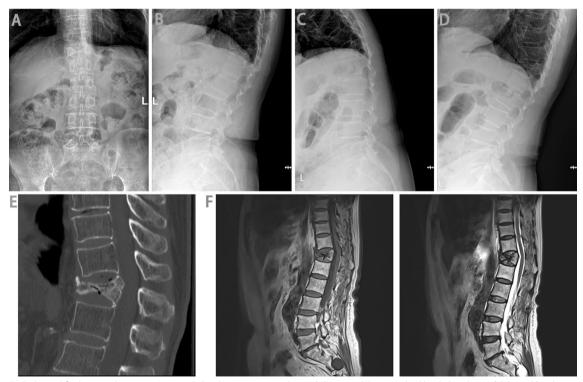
Radiological findings at diagnosis. A Anterior lumbar spine X-ray showed decreased T12 vertebral body height, and B lateral lumbar spine X-ray showed wedge shaped T12 vertebral body and a kyphosis Cobb angle of 28°. X-ray results showed that the Cobb angles at (C) flexion and (D) extension stress position were 33° and 25°, respectively. Computed tomography (E) revealed intravertebral vacuum cleft, and magnetic resonance imaging (F) indicated that the T12 vertebral fracture was not healed
